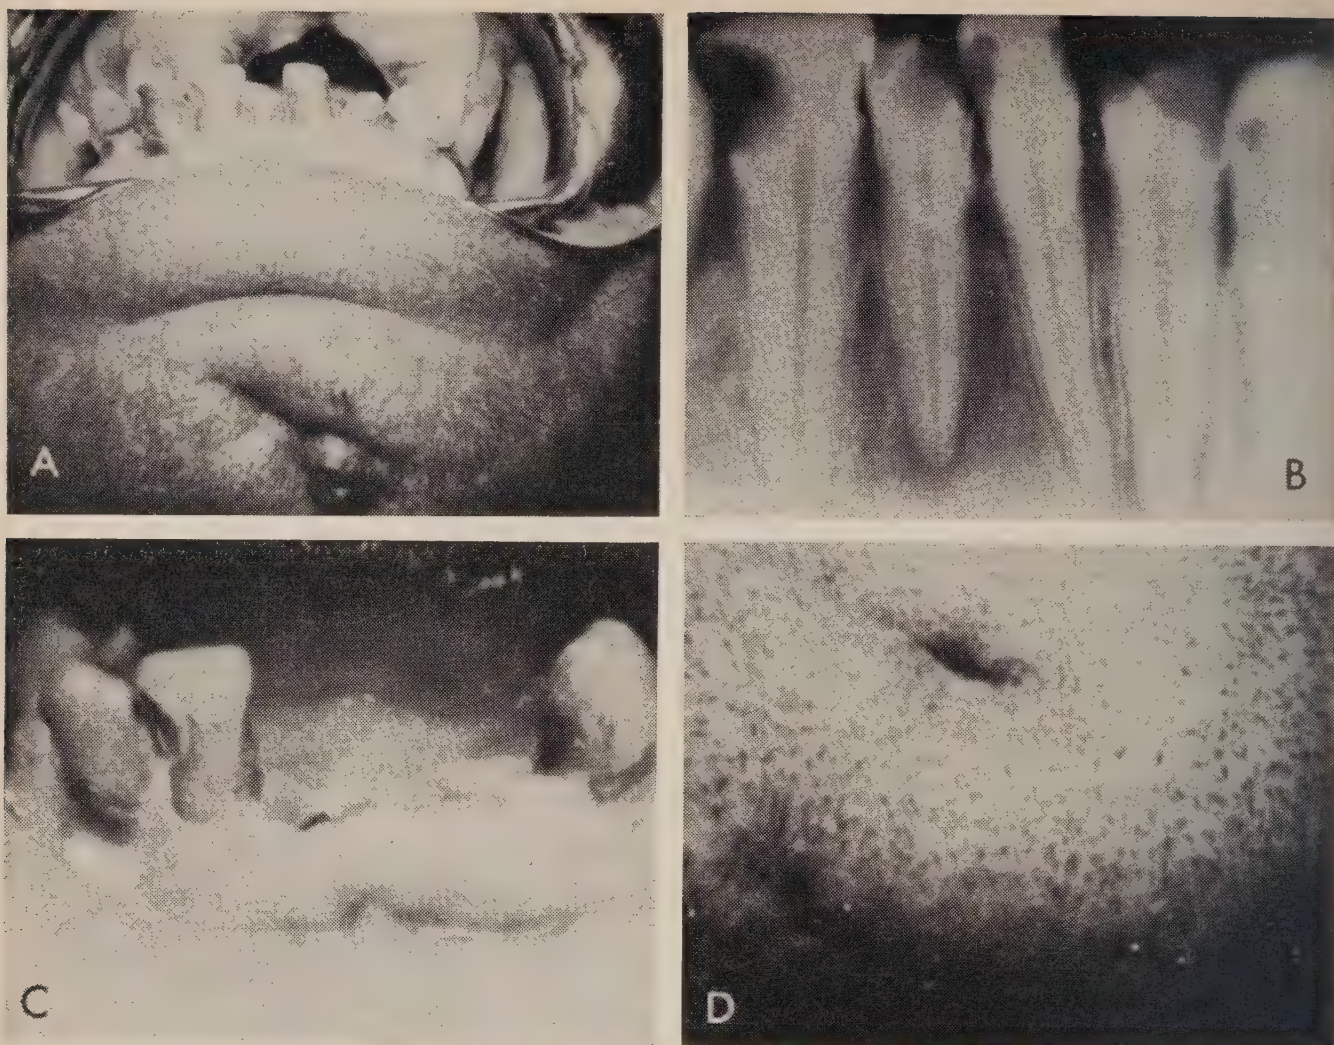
Patient 1: mild haemophilia A. A, Pre-operative condition of the teeth. Note actively draining extra-oral fistula at the base of the chin. B, Periapical radiograph showing caries in the lower incisor and periapical radiolucency in the central and left lateral incisor region. This was the source of the fistula at the base of the chin. C, Postoperative view on the fifth day after extraction. D, One month after removal of the teeth that caused the fistula. The site of the operation is well healed.
